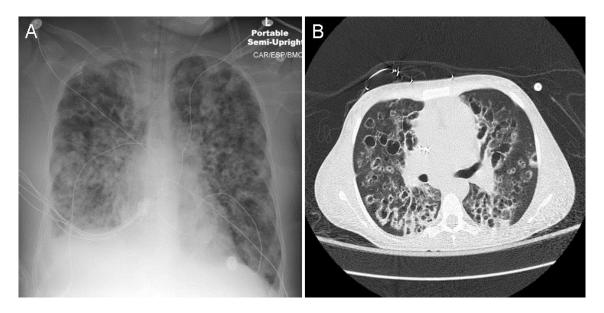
Chest x-ray AP (Panel A) and representative image from chest CT scan (Panel B).
